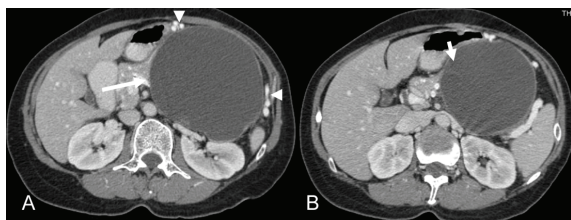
A 45 year-old female with LUQ pain. Axial post contrast CT scan (A,B) showed large well-defined multilocular macrocystic lesion at body and tail of pancreas (long arrow in A). Splenic vein compression with collateral vessel (arrow head in A) and partially internal septation (short arrow in B) are noted. She had distal pancreatectomy and splenectomy and pathology revealed mucinous cystadenoma
